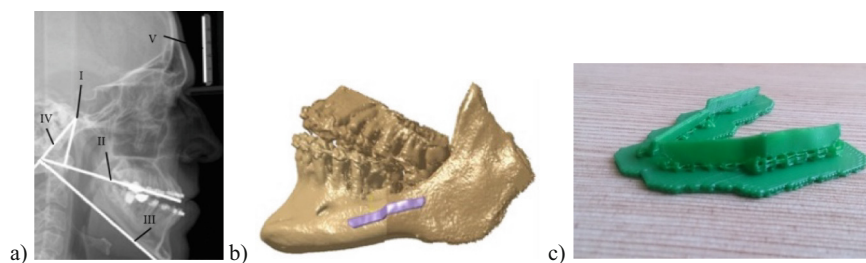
a) X-ray scan with basic geometry b) Solid model of the personalized plate created over scanned data by using MAF c) printed models of the plate implants (left and right) [8, 11].
